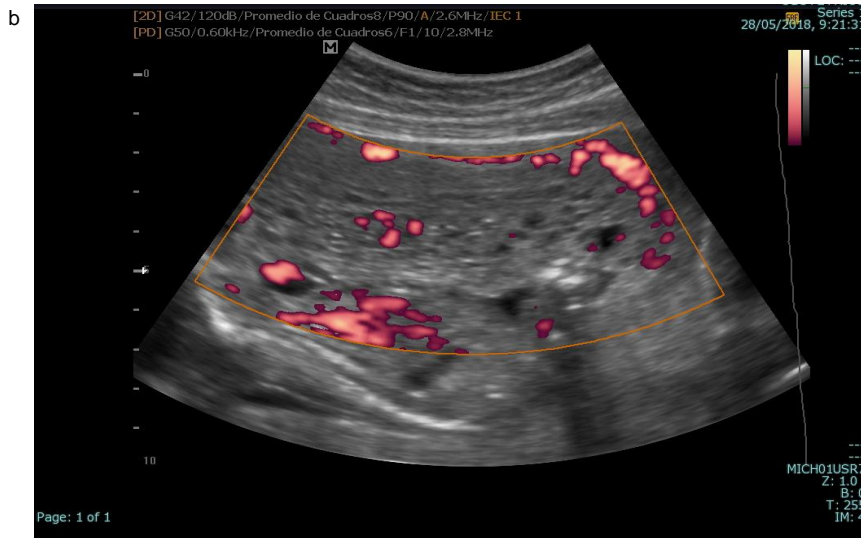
Ultrasound image performed on May 22, 2018, demonstrating alive and healthy fetus with 18±5 weeks of gestation, as well as parts of the molar tissue (a); color doppler performed on May 28, 2018 showing partial mole (b).
